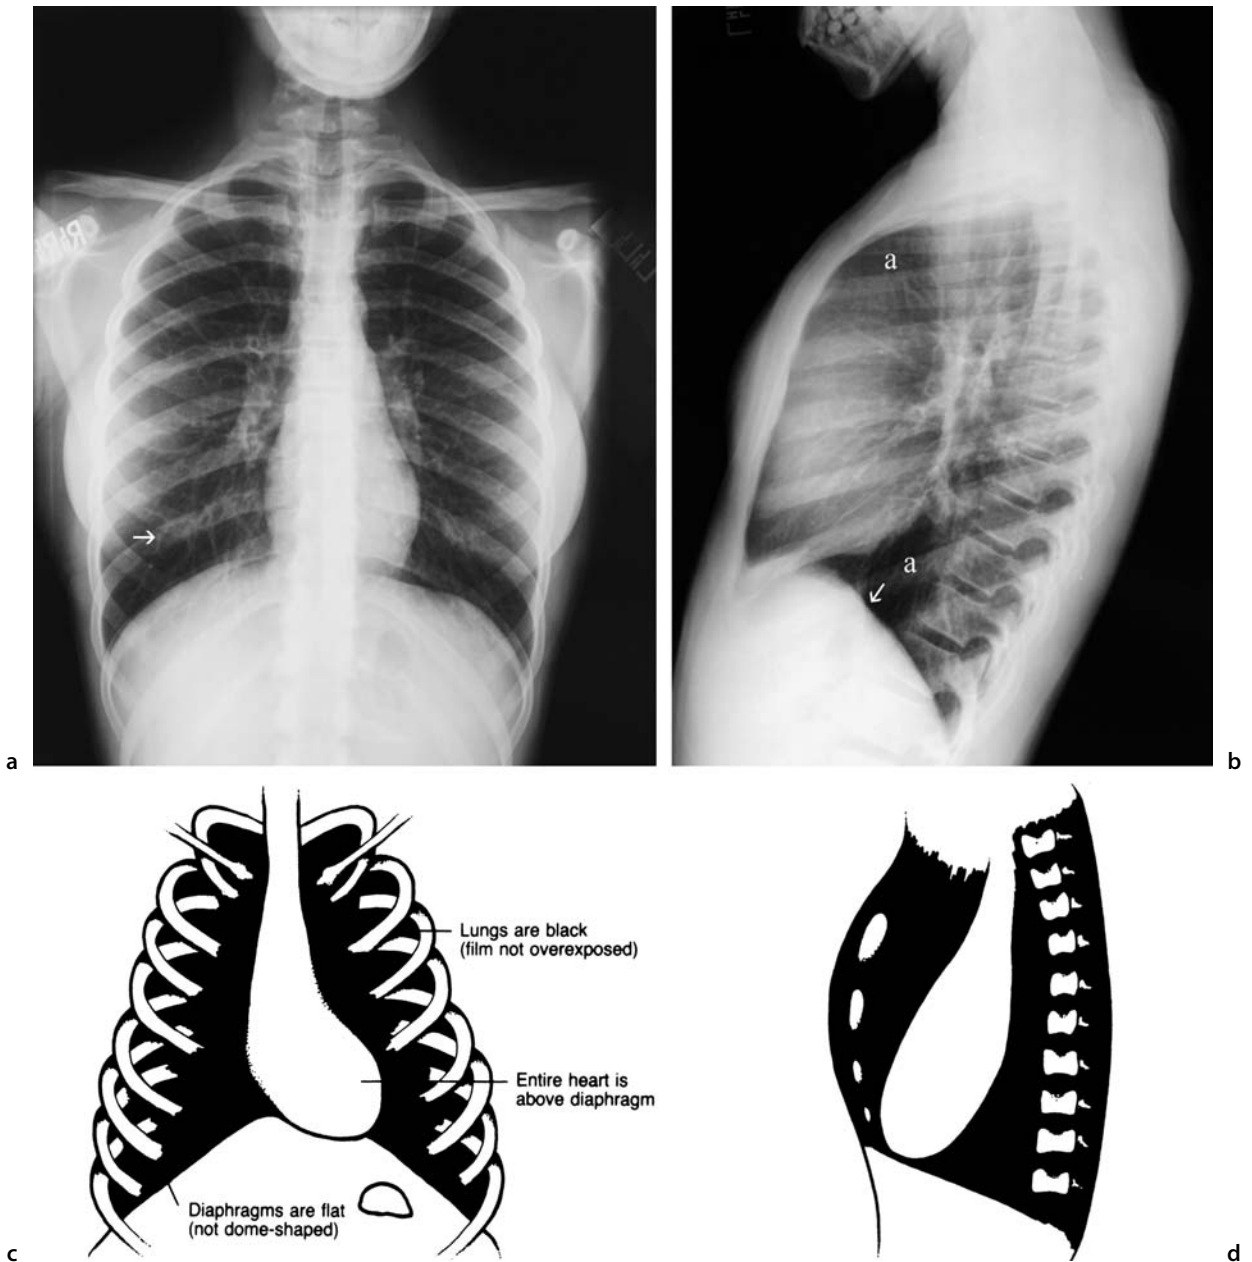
Hyperexpanded chest radiograph
